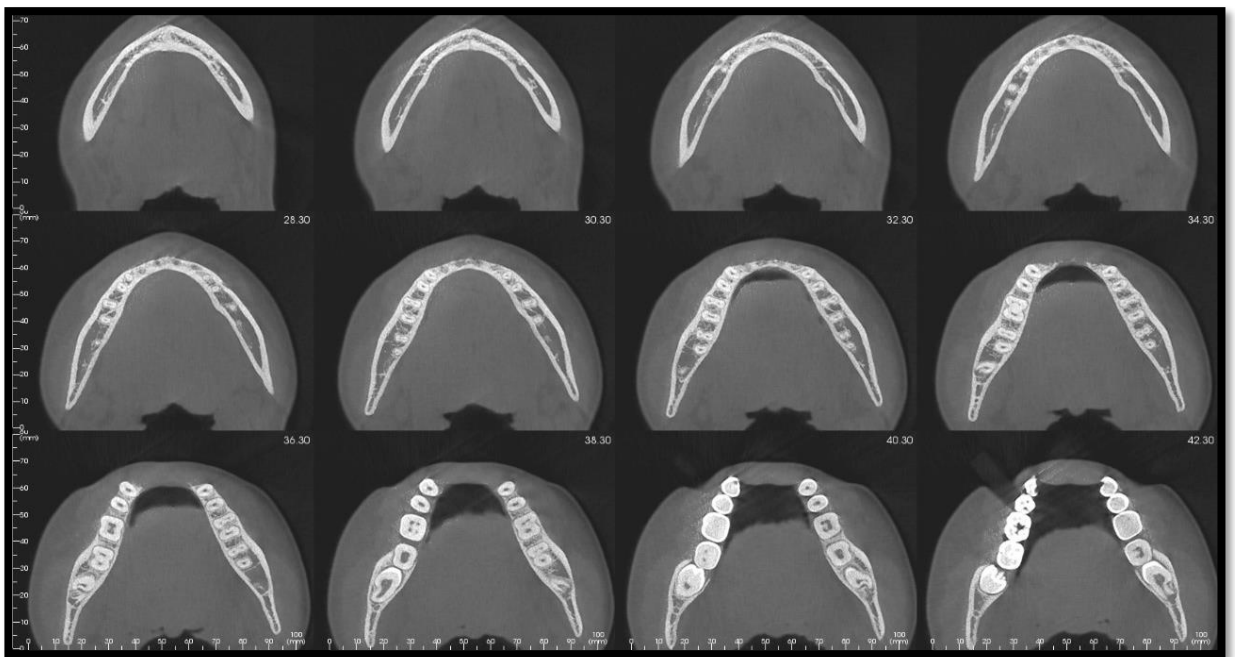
CBCT - axial view
